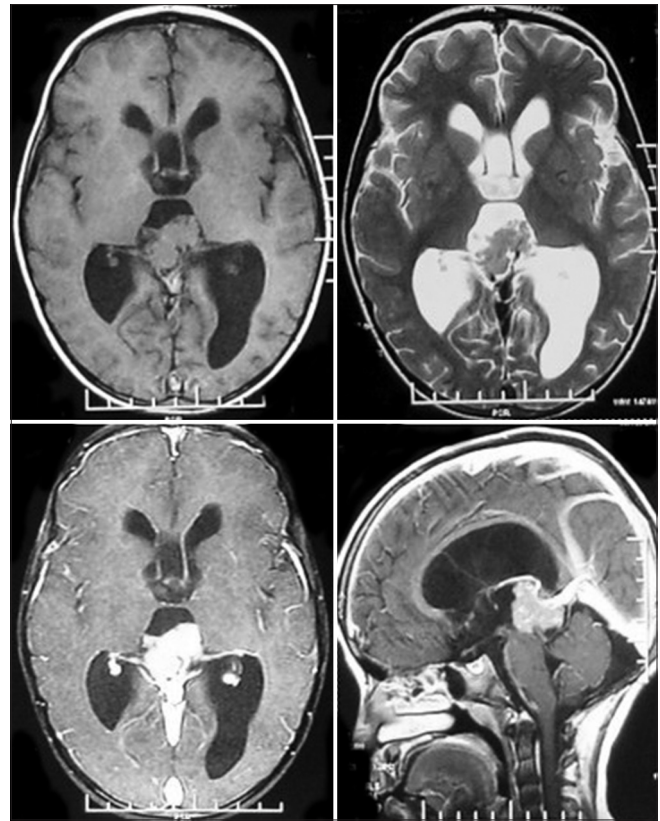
Preoperative T1, T2, and gad MRI showing intraventricular tumor with homogeneous enhancement in posterior third ventricle with obstructive hydrocephalus
